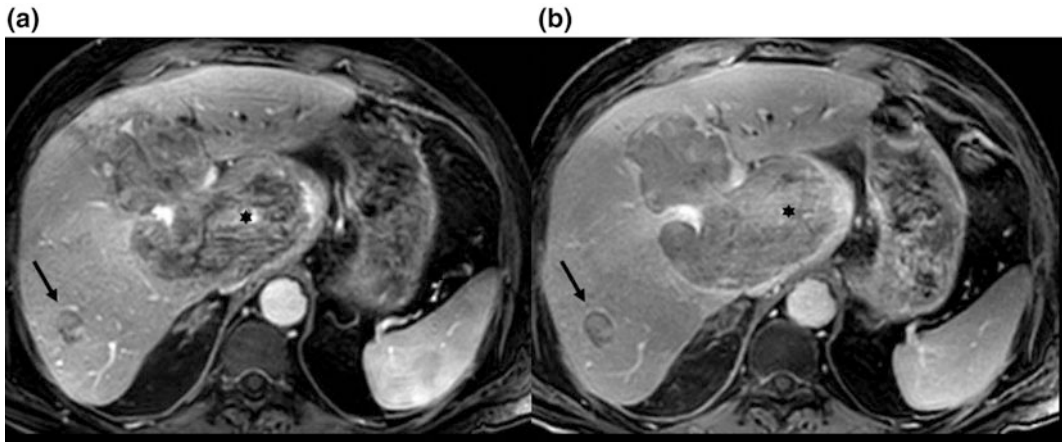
Axial images from an MRI with gadolinium showing a large hepatocellular carcinoma (*asterisks*) and a small HCC (*arrows*) with enhancement in the arterial phase (a) and washout appearance in the portal venous phase (b)
